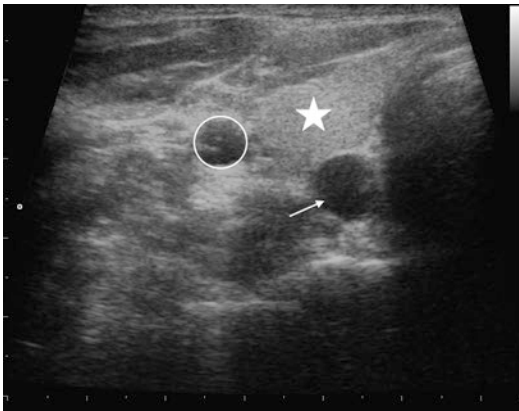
Ultrasound of the right parathyroid adenoma (*arrow*) posterior to the inferior pole of the thyroid (*star*); carotid artery is seen lateral to the gland (*circle*)
